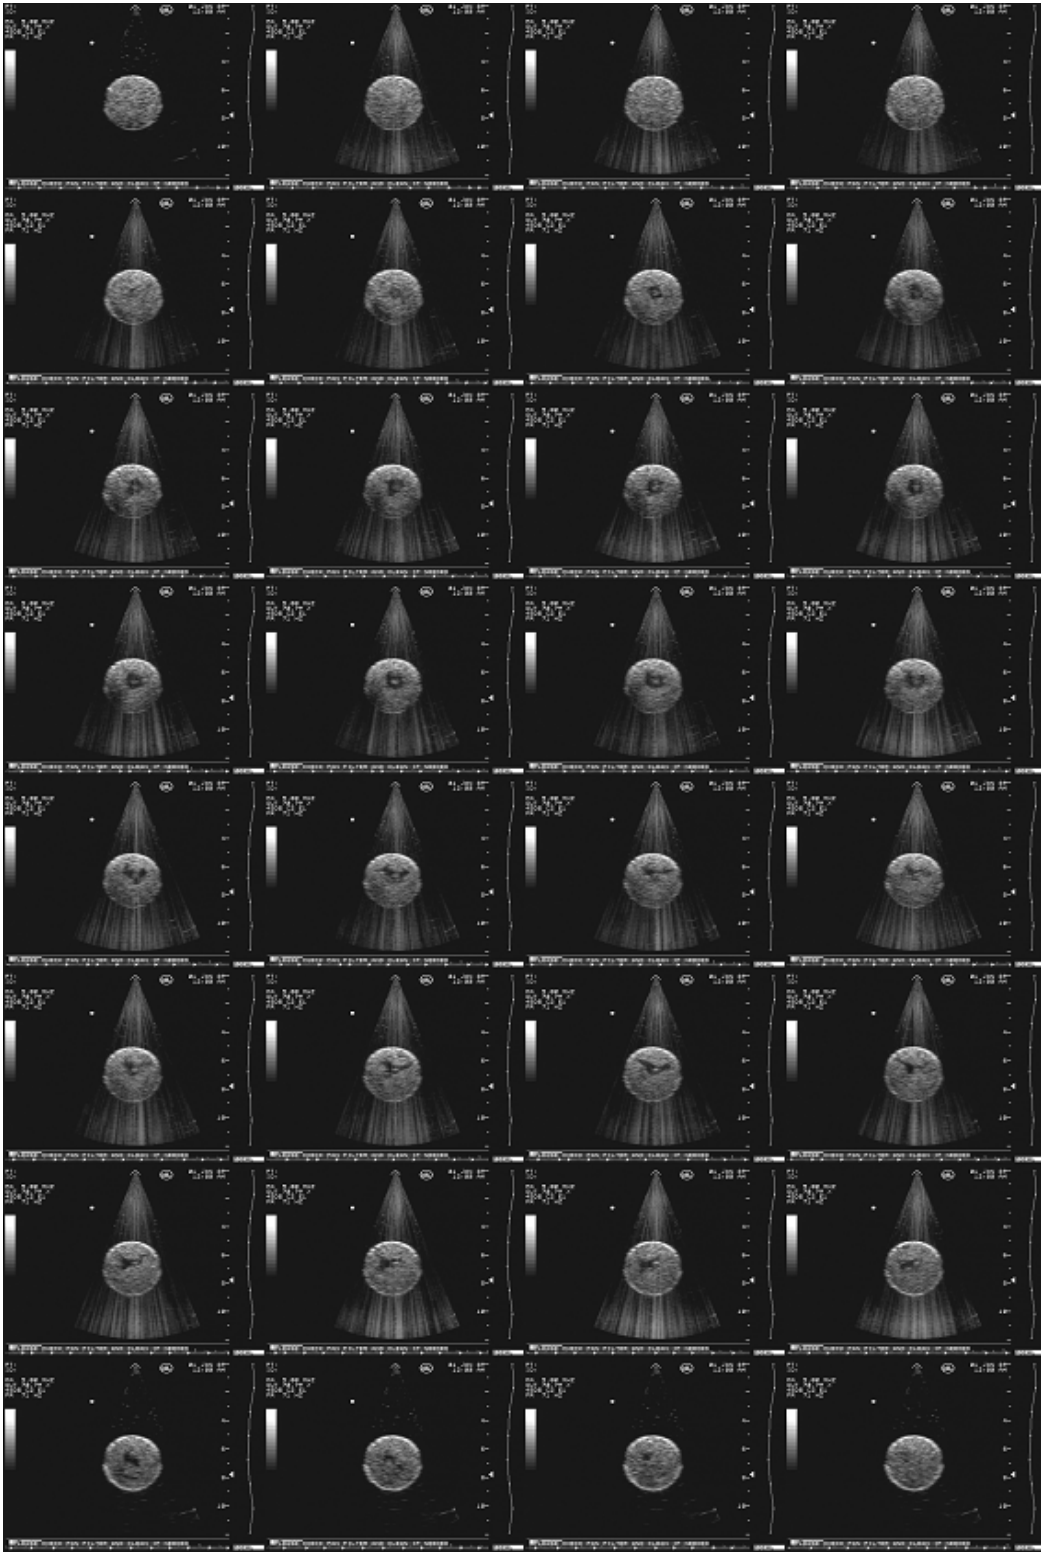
Definity under ultrasound excitation.
